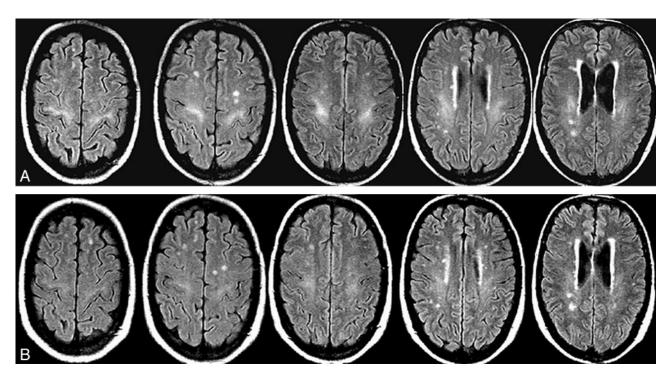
A, Transverse T2-weighted fast FLAIR images obtained in a patient with liver cirrhosis during an episode of hepatic encephalopathy. Observe the symmetric areas of increased signal intensity along the corticospinal tract in both cerebral hemispheres. B, This signal-intensity abnormality almost completely reverses on a follow-up study obtained few months later, when the patient showed no signs of overt hepatic encephalopathy.
